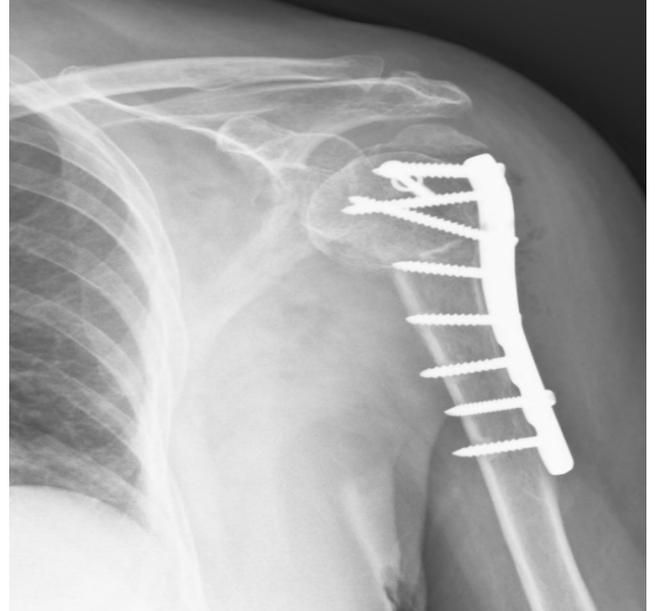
Post-operative x-rays of the patient in the Figure 5, after three months follow up.
